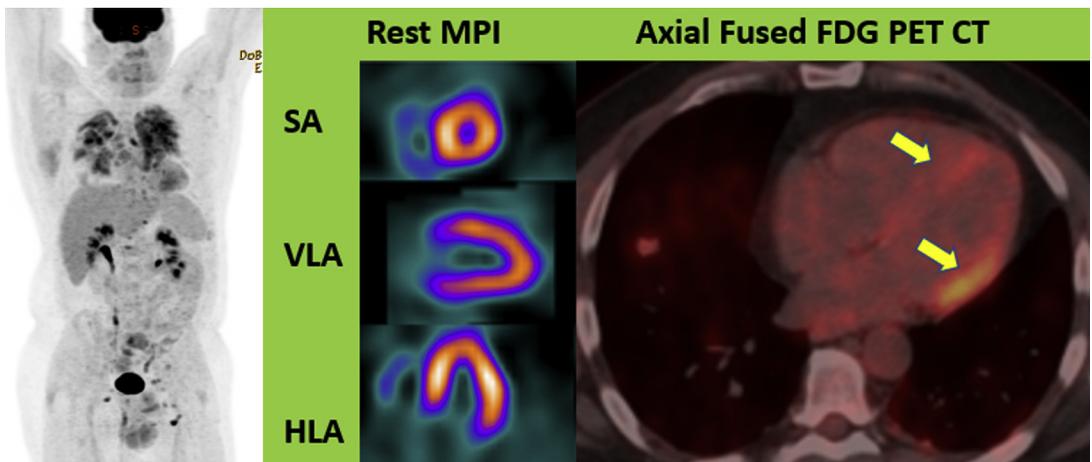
A 57-year-old man with systemic sarcoidosis and right bundle-branch block. Rest perfusion is normal. FDG PET MIP shows extensive active pulmonary disease and hypermetabolic lymph nodes. Fused PET/CT images show active bilateral lung inflammation and patchy areas of FDG uptake involving the septal, anterior, and lateral myocardium, (*arrows*) from early myocardial sarcoid involvement (stage 2).
